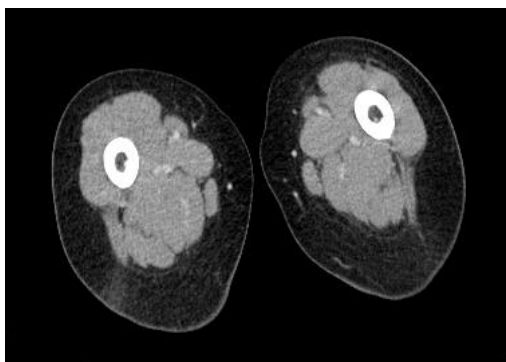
Muscles of the left rectus femoris and hamstring were decreased in the computed tomography venography
